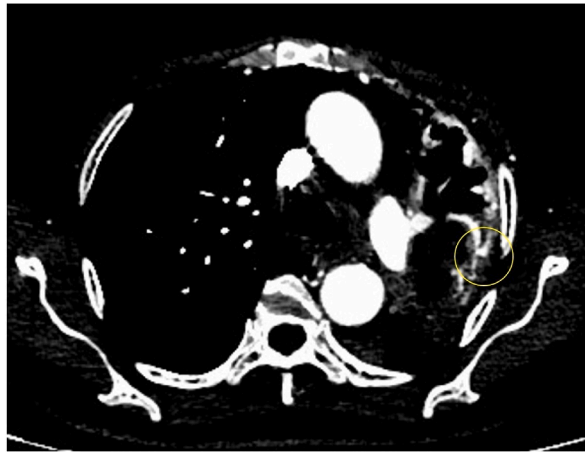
Case 2: CT angiography showing an aneurysm originating from a left upper lobe segmental pulmonary artery branch (encircled).
